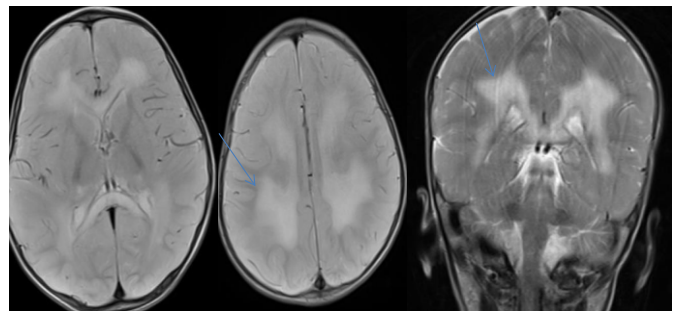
FLAIR axial images show confluent symmetrical hyperintense areas in the fronto-parietal white matter and corpus callosum (arrows)
